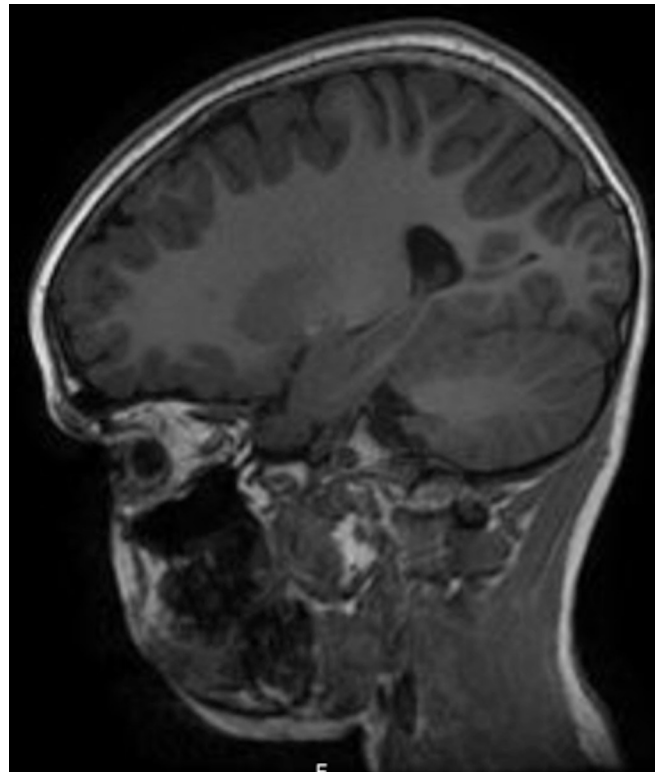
CT sagittal T2-weighted image on MRI, showing relationship with the hypoglossal canal.
